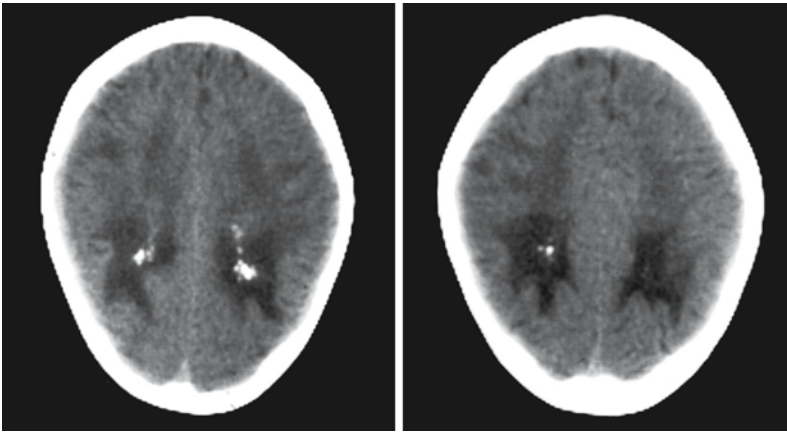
CT scan of an 8-year-old boy with cerebral XALD shows calcium deposits in the lesion
